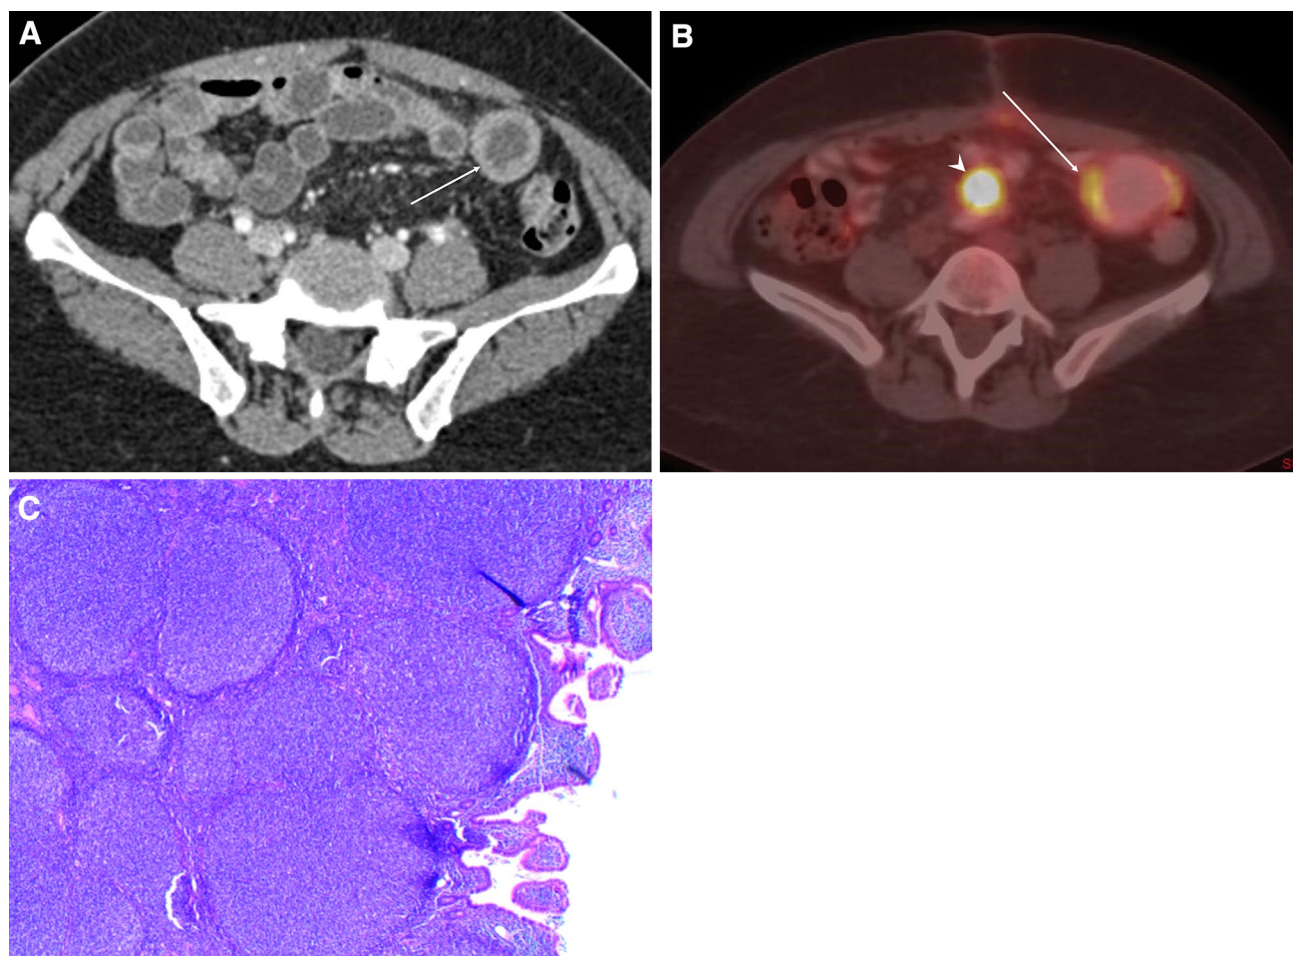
Primary small bowel lymphoma in a 47-year-old female with abdominal pain and vomiting for three months. Axial image from CTE (A) shows an abnormal loop of small bowel with irregular nodular wall thickening and aneurysmal dilatation (*arrow*). Axial fusion image from PET/CT (B) shows FDG
